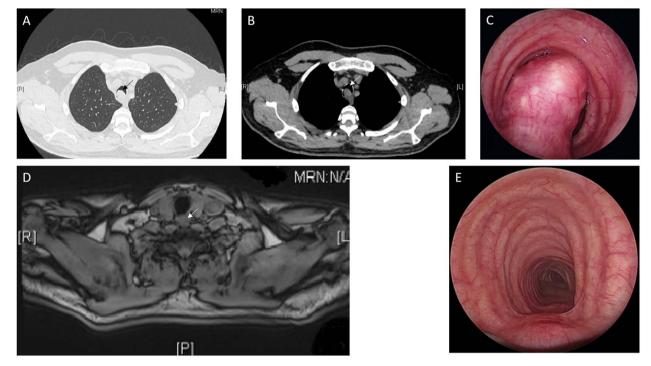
(A, B) Computed tomography of the chest revealed a hypodense round lesion on the posterior wall of the trachea without clear retrotracheal limit (arrows). (C) Endoscopic view of the tumor involving the trachea with infiltration of the posterior surrounding tissue. (D) Post-procedural MRI with retrotracheal residual contrast enhancement (arrow). (E) Post-procedural endoscopic tracheal macroscopic aspect 6 weeks after tumor resection.
